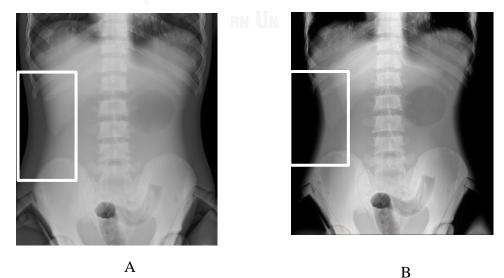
The 21 cm thickness of abdominal radiography (A) 70 kVp, 3.2 mAs and (B) 90 kVp, 25 mAs. The edge of the abdominal wall of the x-ray image in the rectangular box in (B) is disappeared due to using high exposure parameter.
